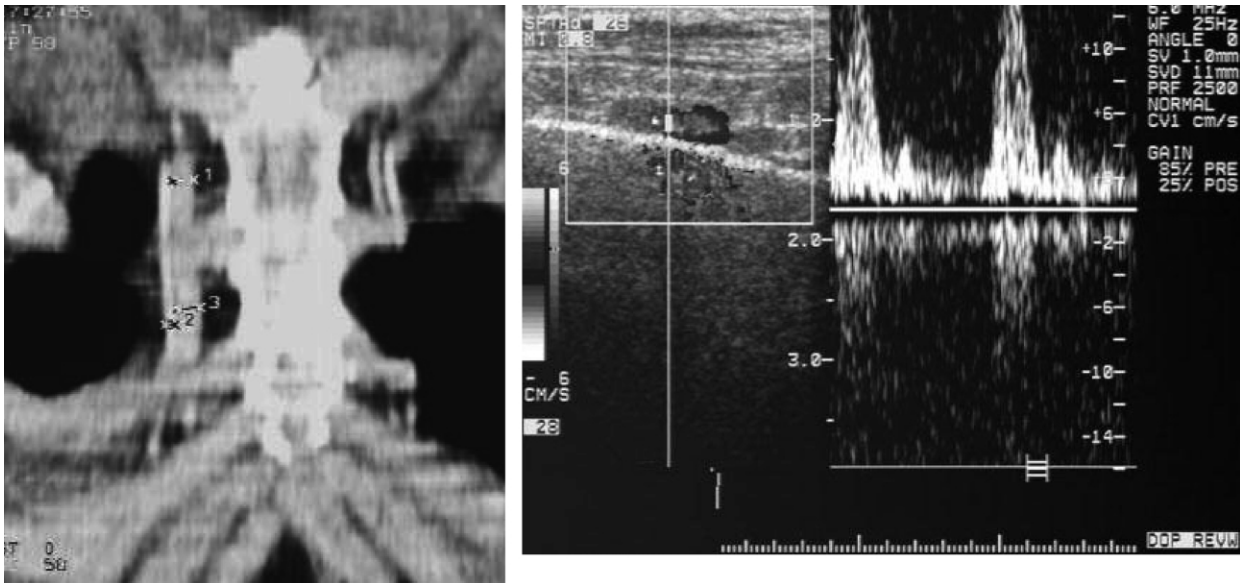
2-Dimensional reconstructed computed tomography and Duplex Doppler sonography image for right internal mammary vessels in a patient. (Left) Coronal 2-dimensional computed tomography shows medially located larger right internal mammary vein (measurement 1, 3) and laterally located smaller internal mammary artery (measurement 2). Measurements were done in 2nd and 3rd intercostal spaces, respectively. Left internal mammary vessels are partially seen in 2nd and 4th intercostal spaces. (Right) Duplex Doppler sonography image shows right internal mammary vessels. Laterally located smaller vessel shows arterial flow.
